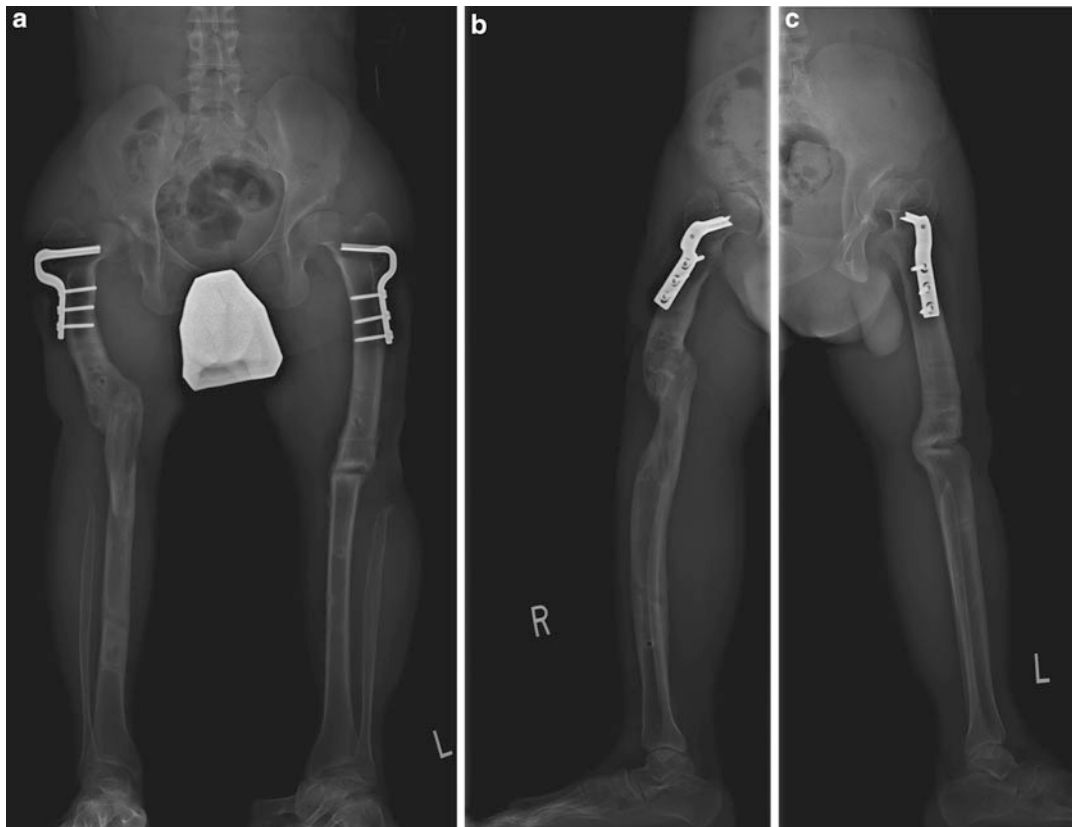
(a–c) Full-length weight-bearing AP and lateral radiographs 6 months after removal of the external fixators. Note the left osteotomy has only partially healed
